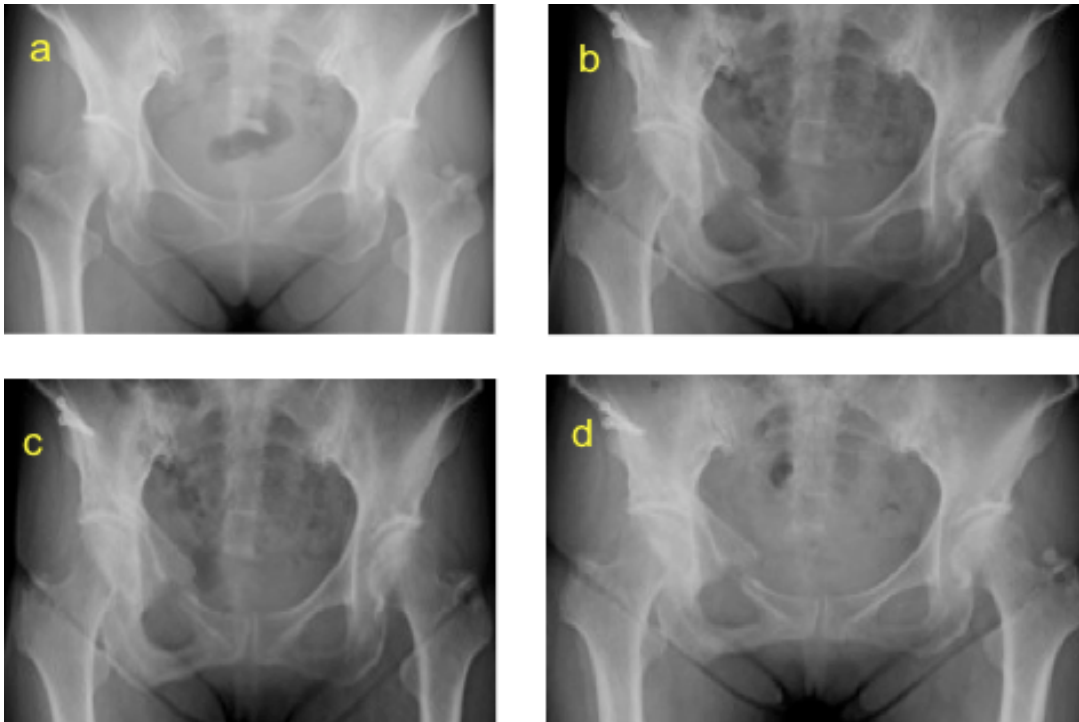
Radiographs of a 66-year-old female patient who underwent curved periacetabular osteotomy for hip dysplasia. a: Preoperative anteroposterior radiograph; b: Postoperative anteroposterior radiograph; c: There was no bone continuity of the superior pubic ramus on anteroposterior radiographs taken 1 year postoperatively; d: There was nonunion of the superior pubic ramus at final follow-up (5.2 years postoperatively)
